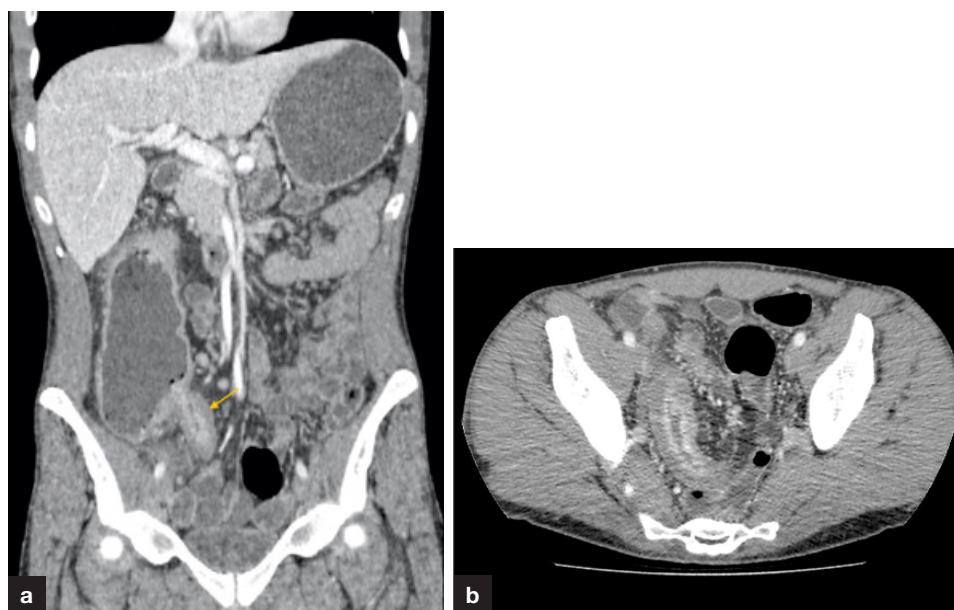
a. Coronal and (b) axial contrast-enhanced computed tomography abdomen and pelvis study performed during an acute 'flare' of Crohn's disease. The terminal ileum is thickened and oedematous, with mucosal hyperenhancement (arrow), in keeping with acute inflammatory Crohn's disease.
